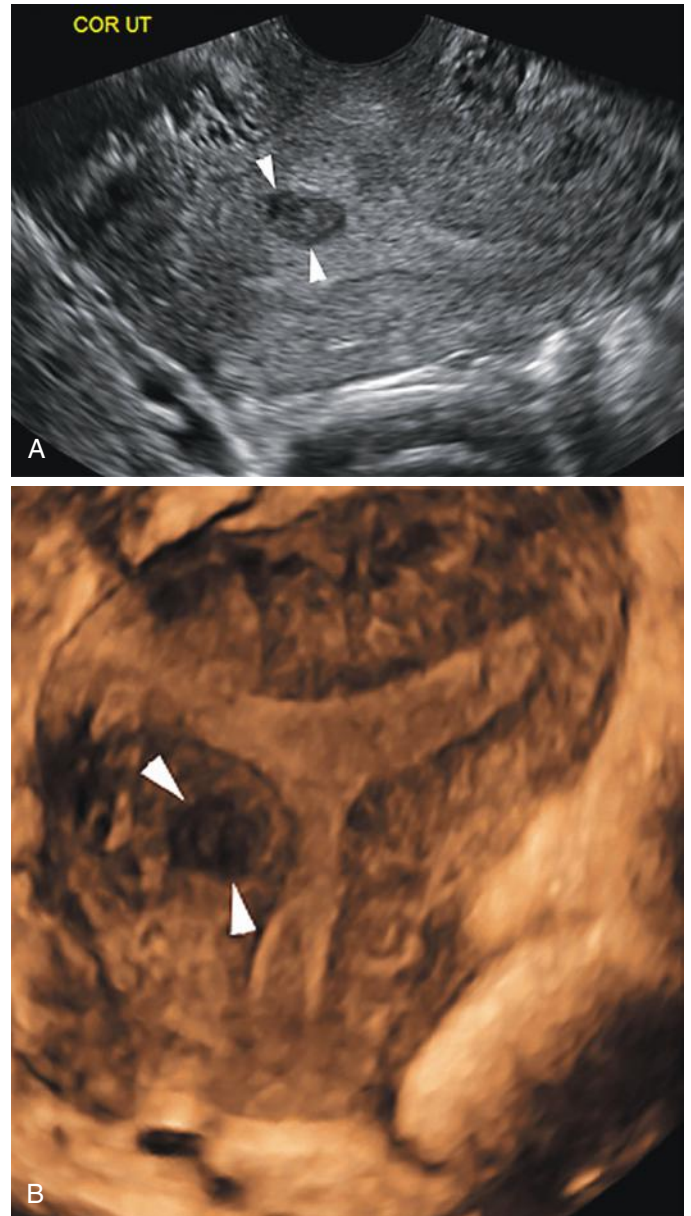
Localization of uterine leiomyoma with three-dimensional sonography. A, Coronal gray-scale transvaginal sonographic image of the uterus shows a small hypoechoic leiomyoma (*arrowheads*) in the central portion of the image. On this projection, the leiomyoma appears to be located within the echogenic endometrial cavity. B, Three-dimensional coronal reconstruction demonstrates that the small leiomyoma (*arrowheads*) is actually located within the right lateral uterine wall completely surrounded by myometrium and therefore is intramural rather than submucosal.
